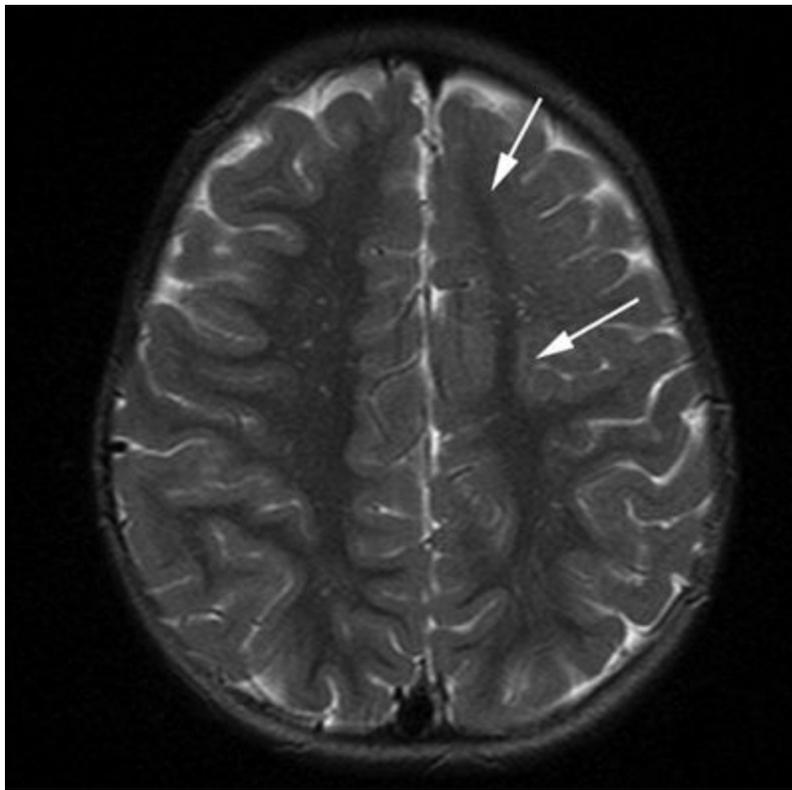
Lobar cortical dysplasia. Axial T2-weighted image from MRI without gadolinium in a 3-year-old with infantile spasms shows generalized blurring of the gray–white interface with lack of normal white matter arborization in the left frontal lobe (arrows).
